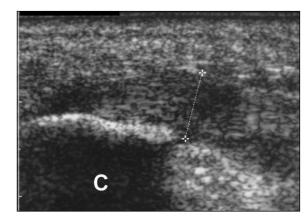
57-year-old women with chronic heel pain. Longitudinal sonogram of sole reveals thickened insertion of plantar fascia into calcaneus (C). Plantar fascia at leading edge of calcaneus was found to be abnormally thickened, measuring 7.3 mm deep. Appearances in this clinical context are consistent with plantar fasciitis. Remainder of plantar fascia was unremarkable.
